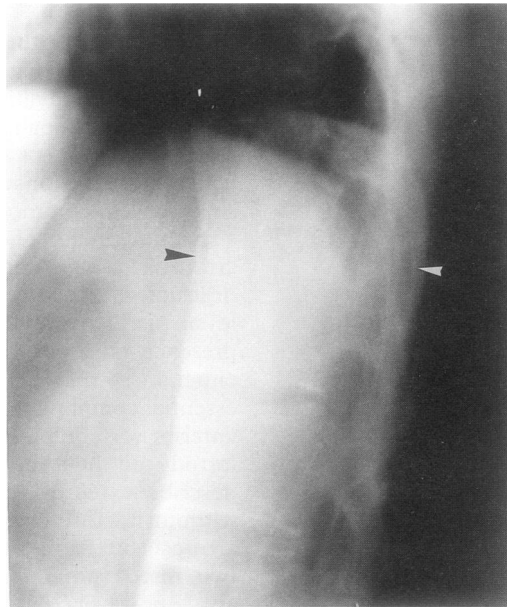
Radiograph taken three years post-surgery shows complete fusion of anterior and posterior elements at the T12/L1 junction (arrowheads).
